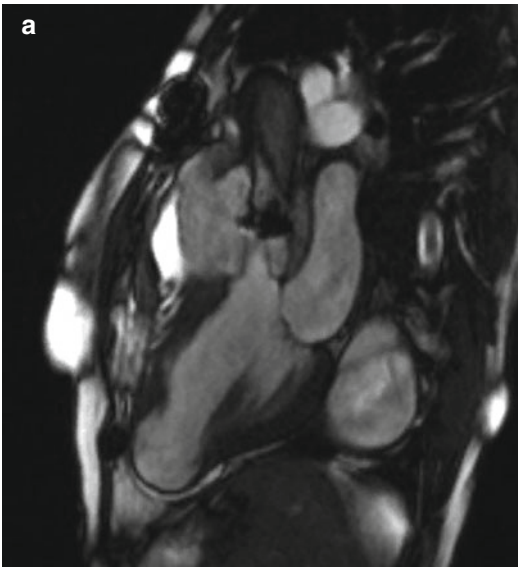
Cardiac MRI images of the mechanical aortic valve dehiscence and circumferential pseudo-aneurysm formation of the valve conduit (a) 3 chamber long axis cine view, (b) chest MRA of the LVOT and aorta. Arrow highlights the pseudo-aneurysm
